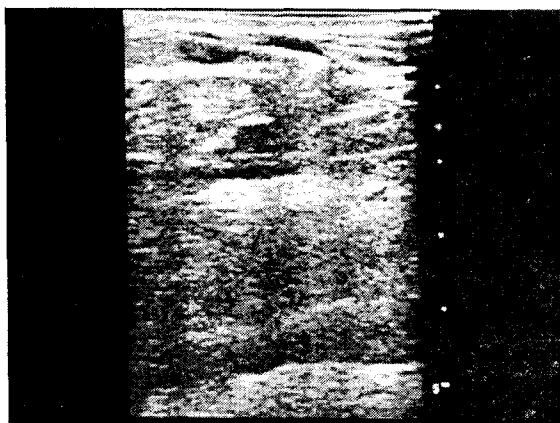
Ultrasound vision of the "Slim" radial laser light in PV.
